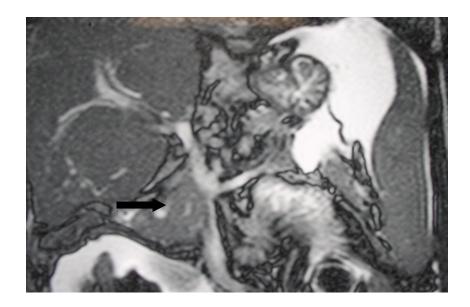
4 MRI Scan-Pancreatic head carcinoma
